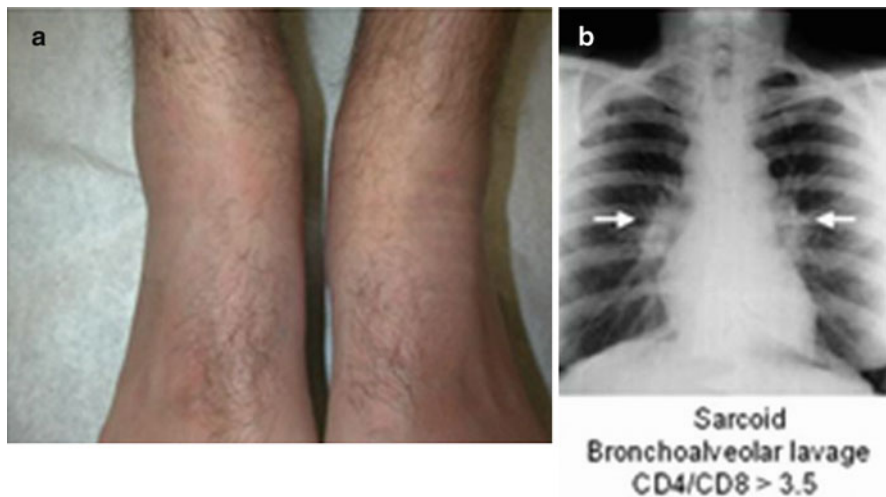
Diffuse periarticular erythema nodosum on the right ankle – a chest X-ray showed large, bilateral adenopathy (*arrows*) consistent with Loeffler's syndrome (sarcoidosis)
